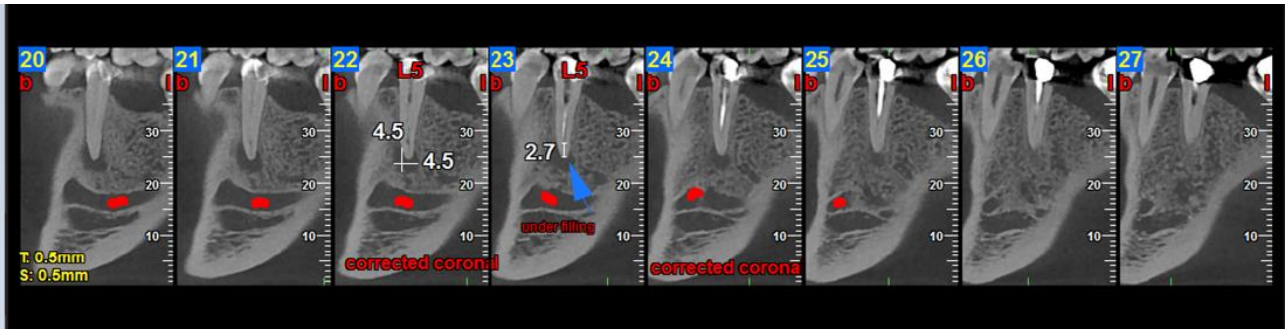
Corrected coronal CBCT image of tooth #20 with root canal treatment.
